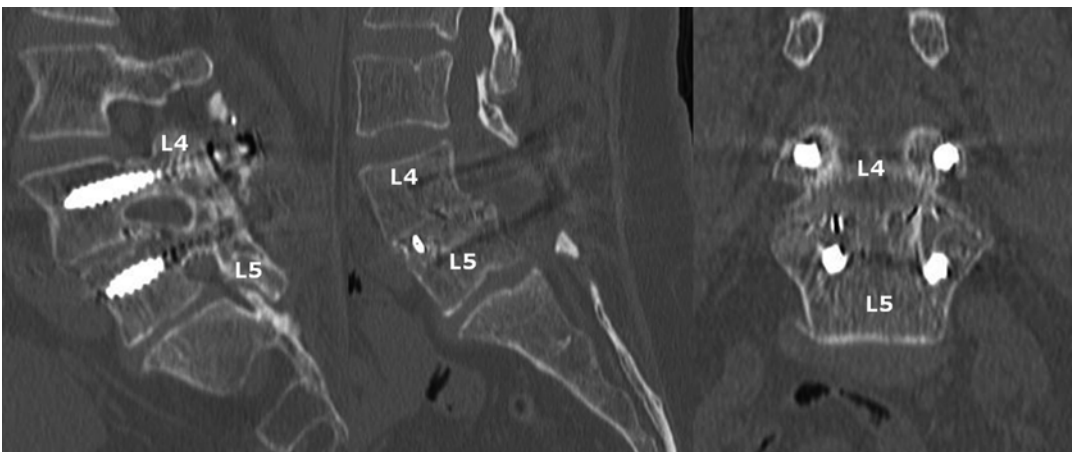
CT scan in sagittal and coronal views that demonstrate a solid fusion with remodelling of the bone graft between L4 and L5 after a PLIF procedure
